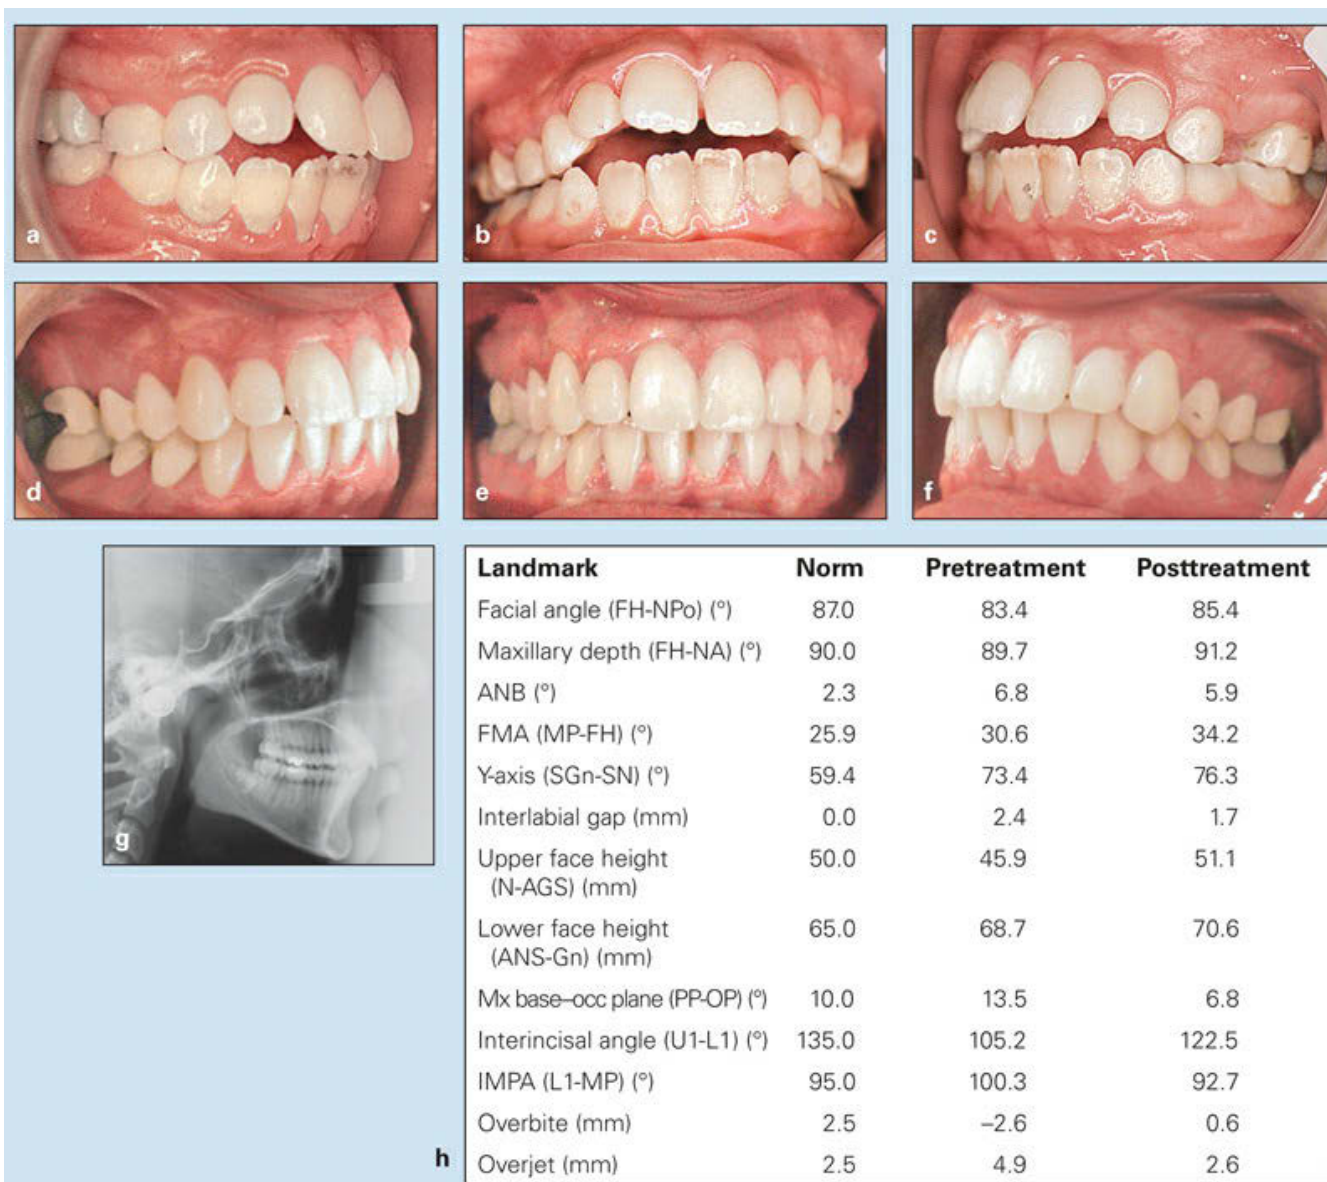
Management of Class I anterior dentoalveolar open bite with maxillomandibular dental protrusion and tongue thrusting in a 9-year, 10-month-old girl. (*a to c*) Pretreatment occlusion. (*d to f*) Posttreatment occlusion. (*g*) Posttreatment cephalometric radiograph. (*h*) Changes in cephalometric measurements.
